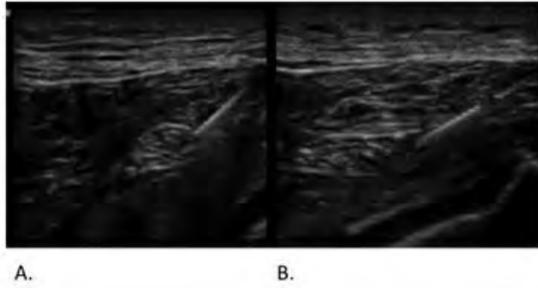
Ultrasound images of the (A) direct needle approach and (B) tangential needle approach during injection of dye into the paraneural sheath of sciatic nerve.
